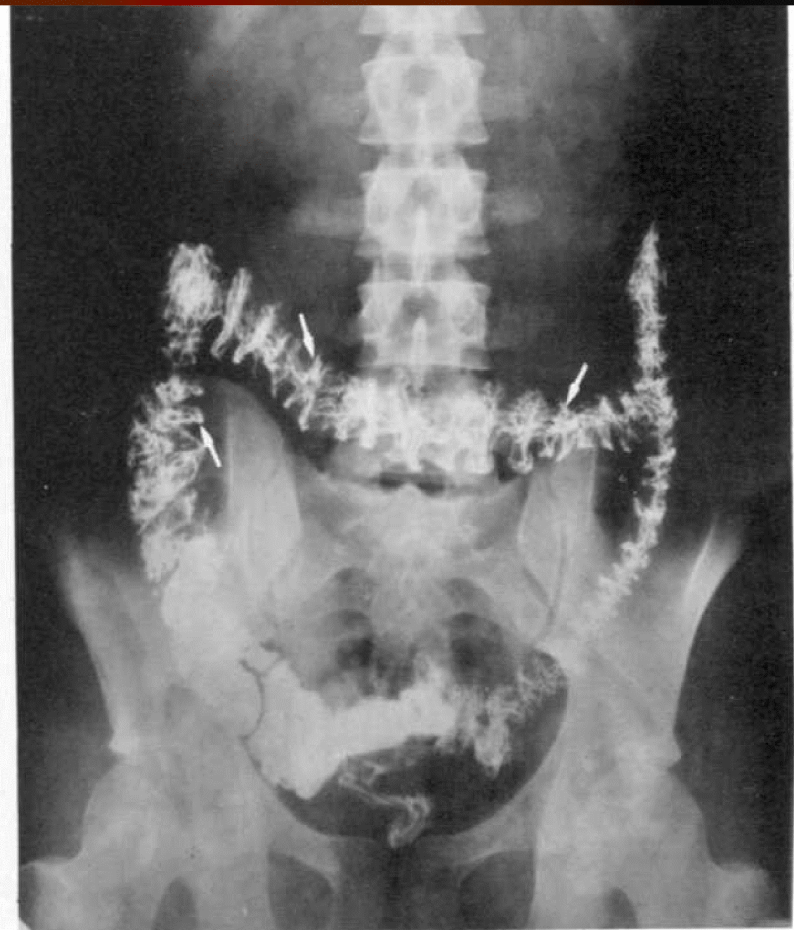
Postevacuation radiograph demonstrating
